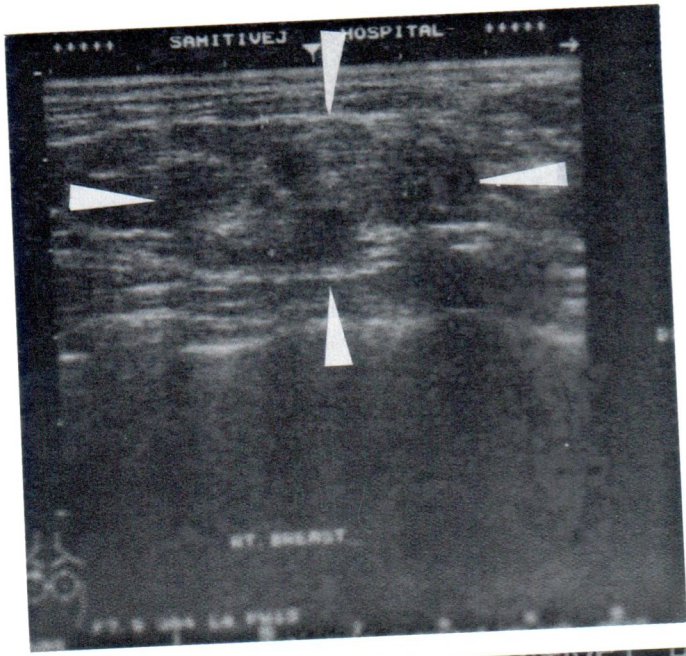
Ultrasonography of the palpable lesion in the breast of the patient No.1 showed multiple iso and low echoic nodules.
